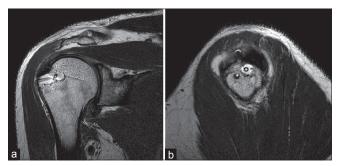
Images showing a large cystic collection around a lateral row bioanchor with anchor breakage. (a) Sagittal and (b) Coronal T2-weighted images
